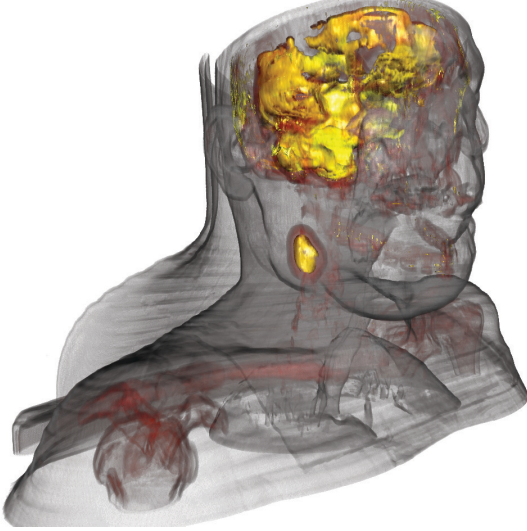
Multimodal visualization of a CT and PET scan. The yellow color symbolizes regions of high activity such as in the brain area and in the tumor on the neck.
